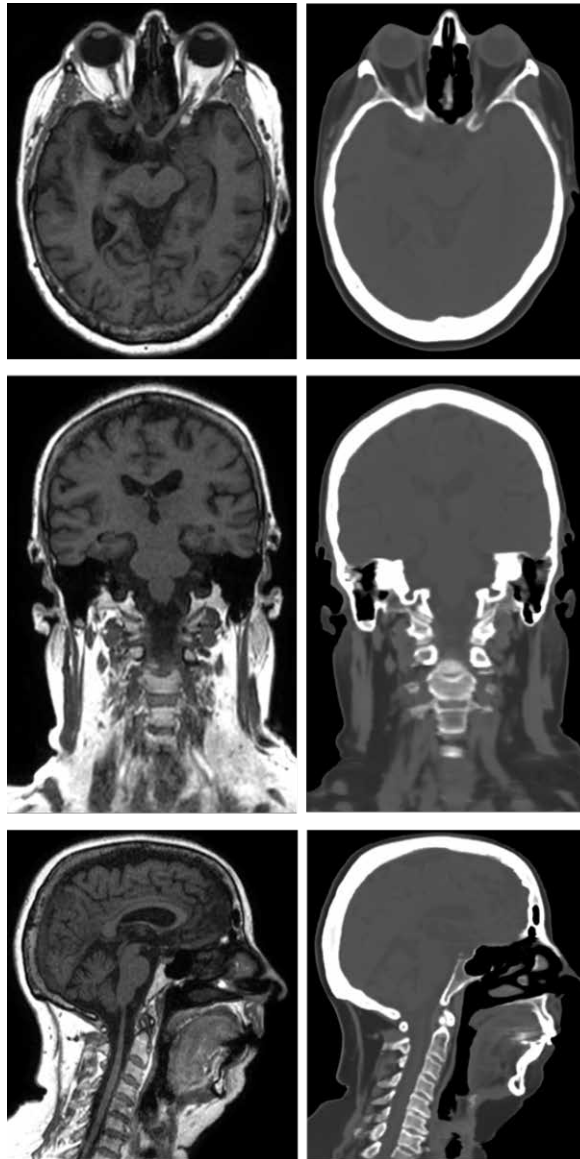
An example of post-processing of MRI data. T1 Dixon In-phase MRI image of the brain (left) and a pseudo-computed tomography calculated from the same MRI image (right). Picture: Courtesy of Turku University Hospital / Department of Oncology and Radiotherapy.
